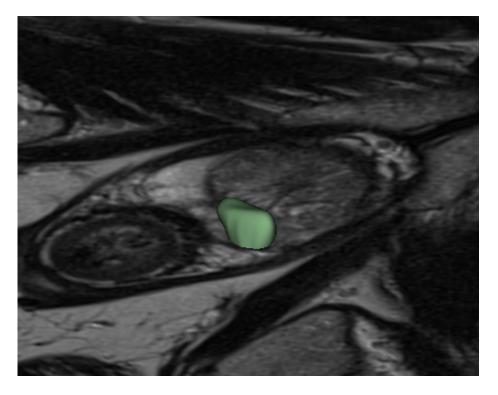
Example of prostate mp-MRI image 3D segmentation showing the entire tumour volume used for radiomic analysis.
